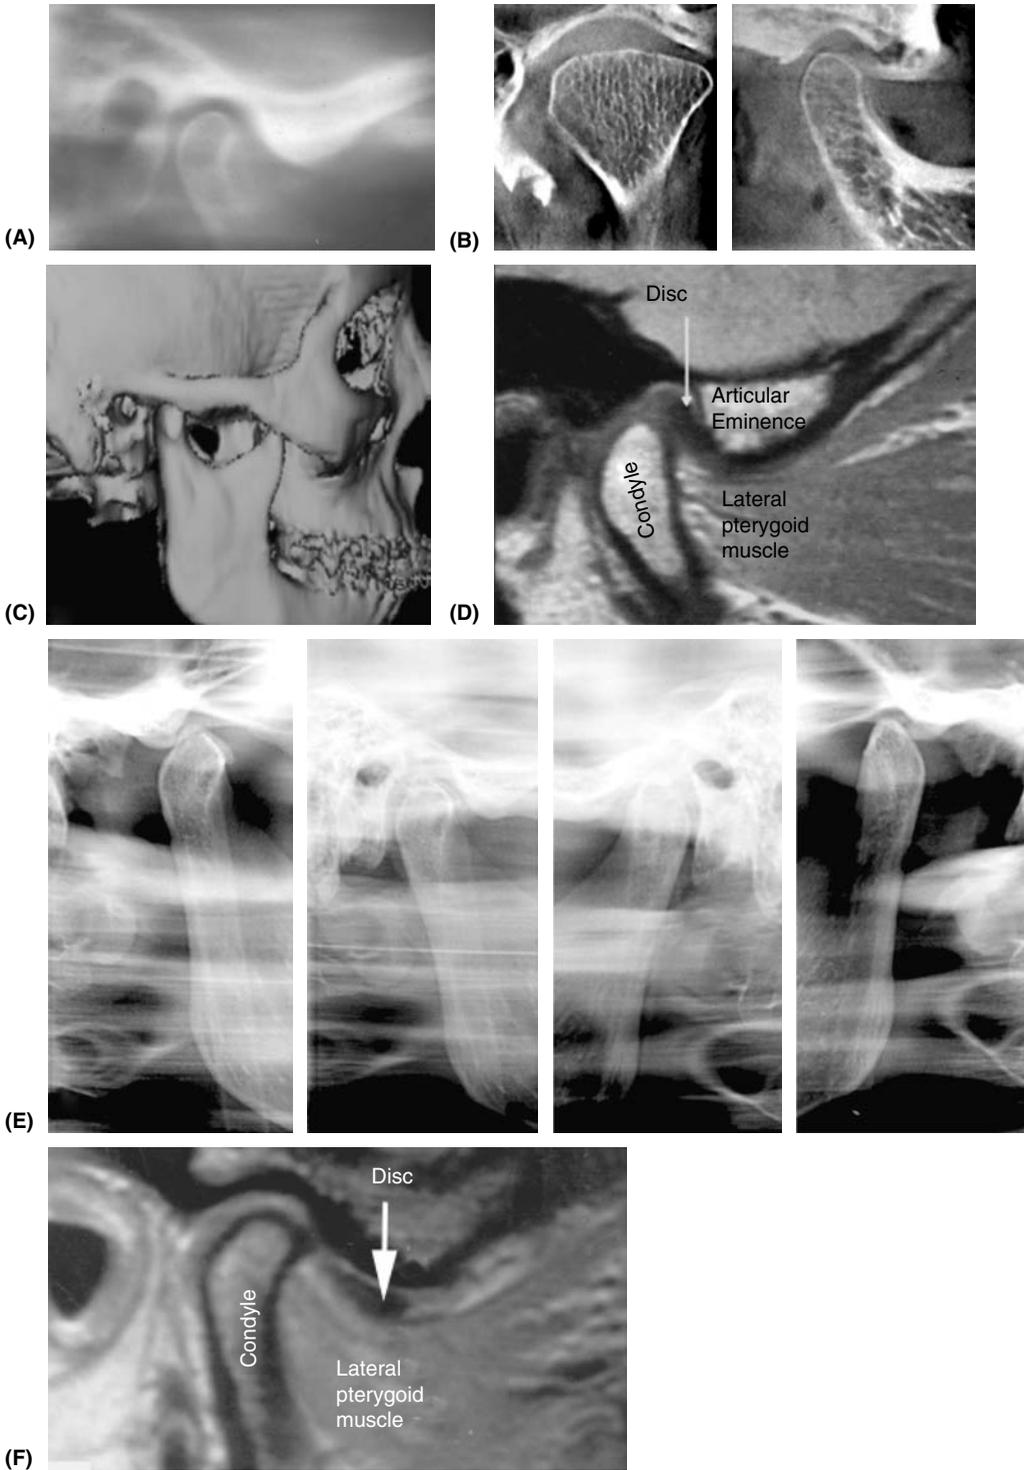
Radiographic evaluation of the temporomandibular joint: (A) orthopantomograph; (B) 2-dimensional computed tomography (CT) scan; (C) 3-dimensional CT scan; and (D) magnetic resonance imaging (MRI). Dynamic assessment can be obtained with (E) open and closed views and with (F) MRI imaging that can show disc displacement.
